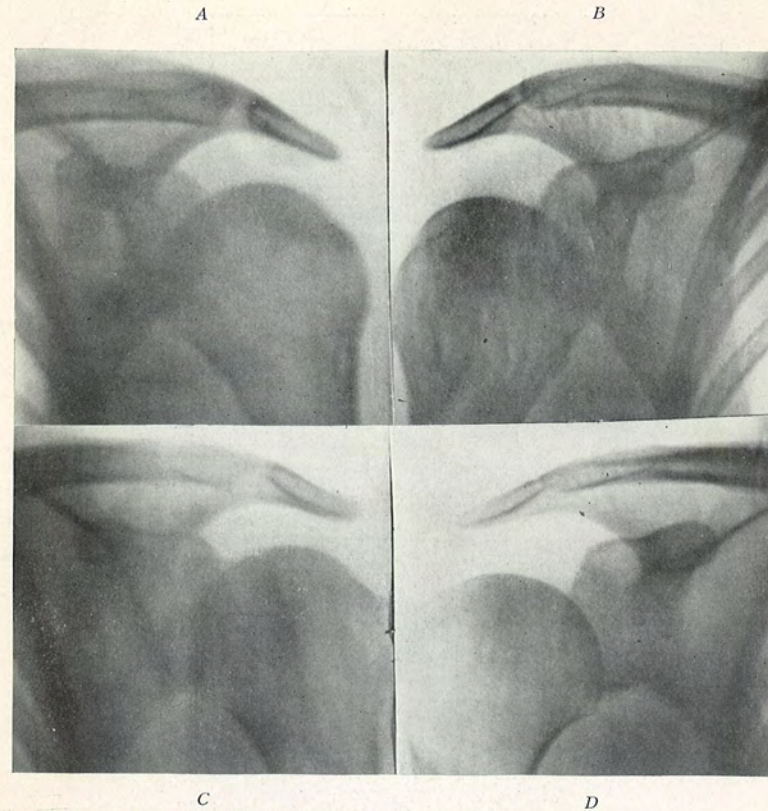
Shows that a flail shoulder-joint, once developed, however slight, probably never can fully recover, because the humeral head cannot go back to its normal level against gravity. *A* and *C*, normal right shoulder; *B* and *D*, affected left shoulder. *A* and *B* taken March 4, 1916, about seven and a half months after beginning of trouble. By directing the X-rays in the plane of the acromion process the widest possible space was obtained between the acromion and humeral head, thus emphasizing the difference between the two shoulders. *C* and *D* were taken May 5, 1917, fourteen months after *A* and *B*, the X-rays being directed in the same plane in all four pictures. The left shoulder has lost none of its laxity, which is, probably, permanent.
